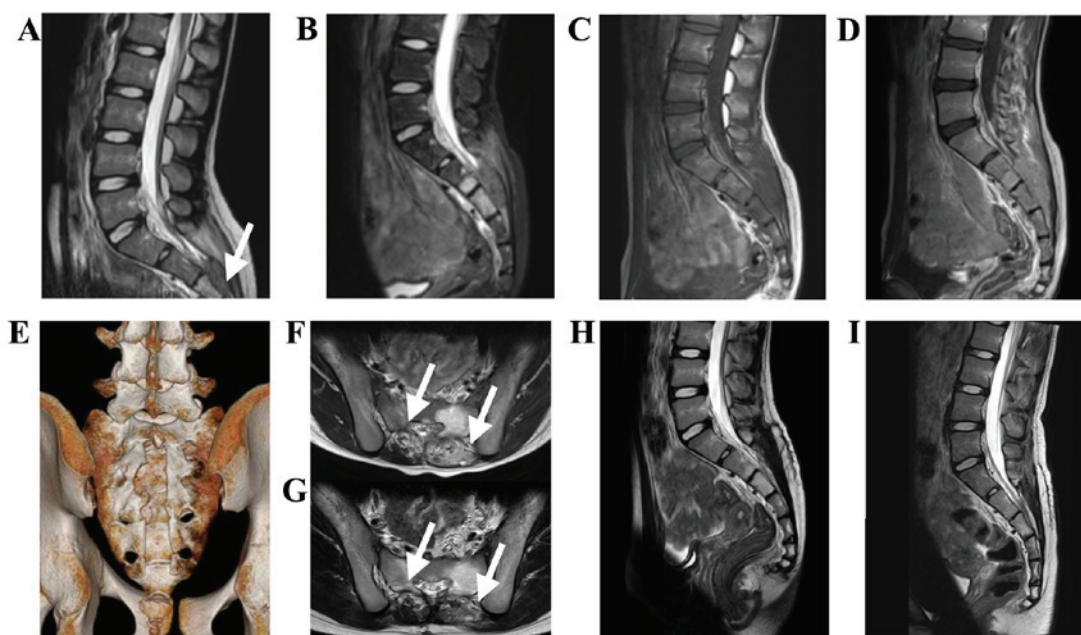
Imaging studies. (A) Magnetic resonance imaging (MRI) examination of the lumbar spine 6 months prior to surgery revealed a lesion (arrow) at the S3 level. The lesion doubled in size on MRI immediately prior to surgery: (B) T2-weighted imaging, (C) T1-weighted imaging and (D) T1-weighted imaging with gadolinium enhancement. (E) Computed tomography scan showing a preoperative 3D bone image. (F) T2-weighted axial image on MRI revealed abnormal intensity in the paraspinal muscles (arrows). (G and H) T2-weighted image on MRI showed no recurrence and reduced abnormal intensity area (arrows) at 3 months after the surgery. (I) T2-weighted image on MRI showed no recurrence and further reduction of the abnormal intensity area at 8 months after surgery.
